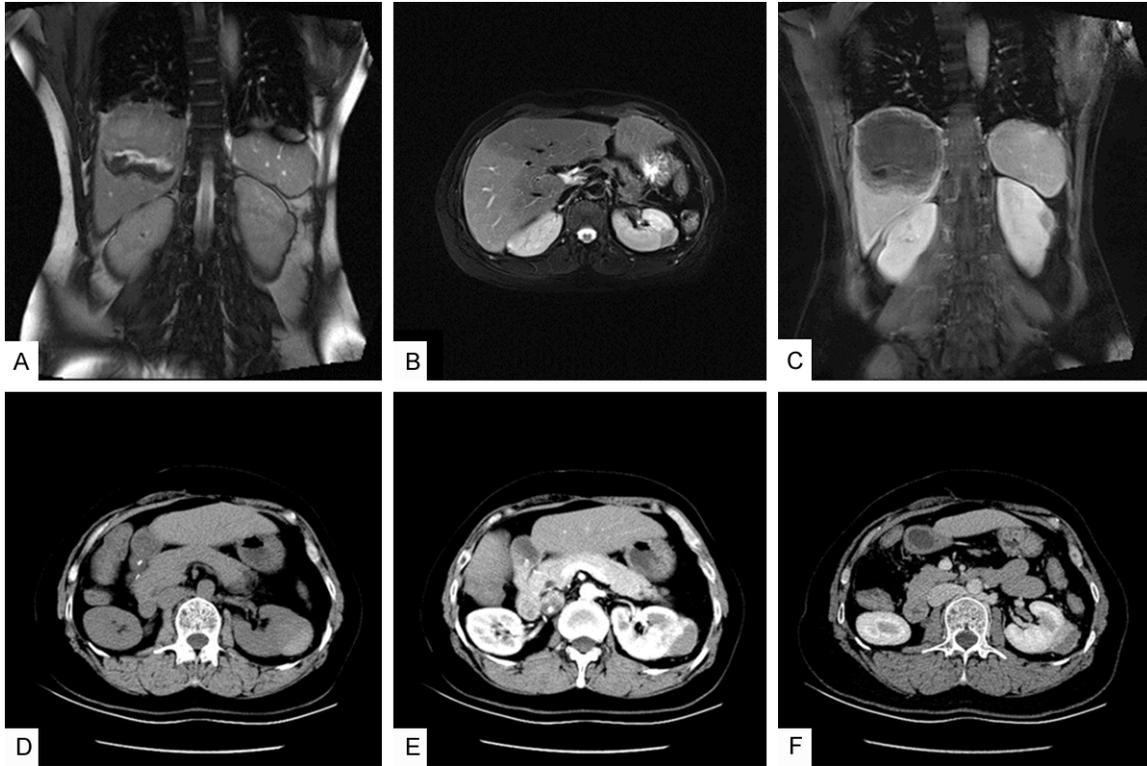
A: Magnetic resonance imaging showed a left kidney mass (2.0 cm × 1.6 cm) with hypointensity on T1-weighted and a heterogeneous mass (10 cm × 10 cm) on T1-weighted in liver. B: MRI showed the left kidney mass with hypointensity on T2-weighted. C: Contrast enhanced T1-weight imaging showed the absence of enhancement of the kidney mass and the liver mass. D: The kidney mass was high-density on computed tomography. E, F: Enhanced CT showed a kidney mass (3.8 cm × 3.3 cm) with the absence of early-phase and late-phase enhancement.
